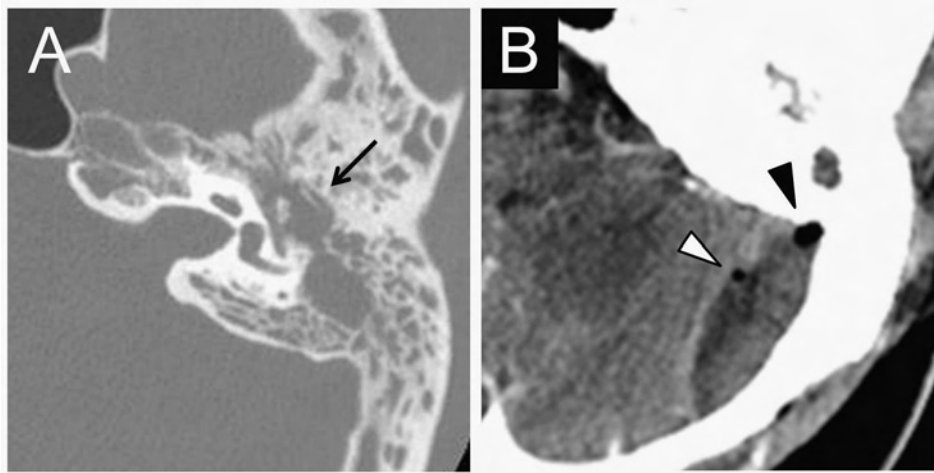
Head CT scans of the axial view showed left tympanomastoiditis without aeration, and contained a hyperdense object lateral to ossicles (arrows) (A), epidural abscess with gas formation (arrowheads) in the posterior cranial fossa and sigmoid sinus occlusion (B).
